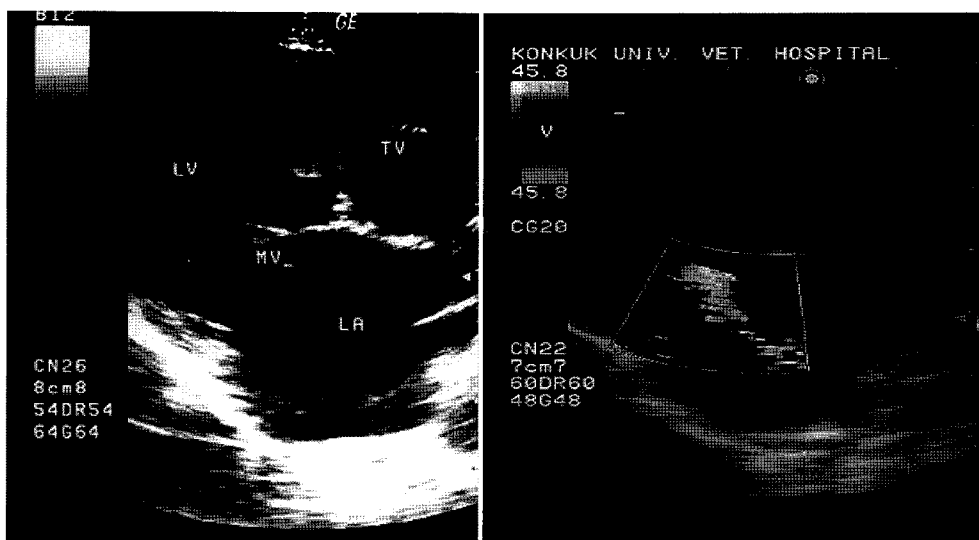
The 2D-echocardiography taken from the right parasternal short axis view. The hyperechoic mass of 7.3 mm diameter was observed in left atrium
